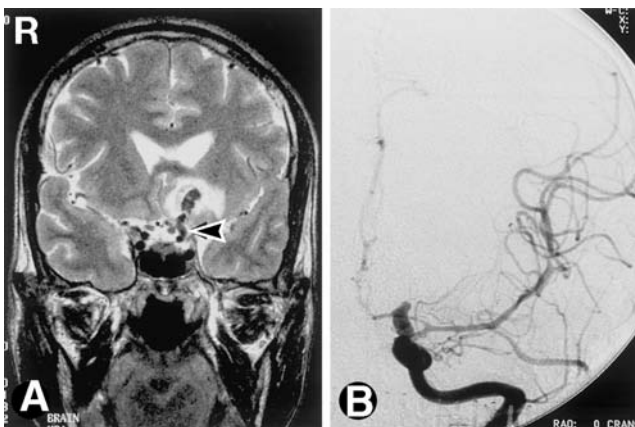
A: Magnetic resonance image revealing a vascular lesion (arrowhead) protruding from the internal carotid artery and extending into the base of the hemorrhage. B: Left internal carotid angiogram disclosing a vertically elongated aneurysmal dilatation of the dorsal wall portion of the internal carotid artery.
